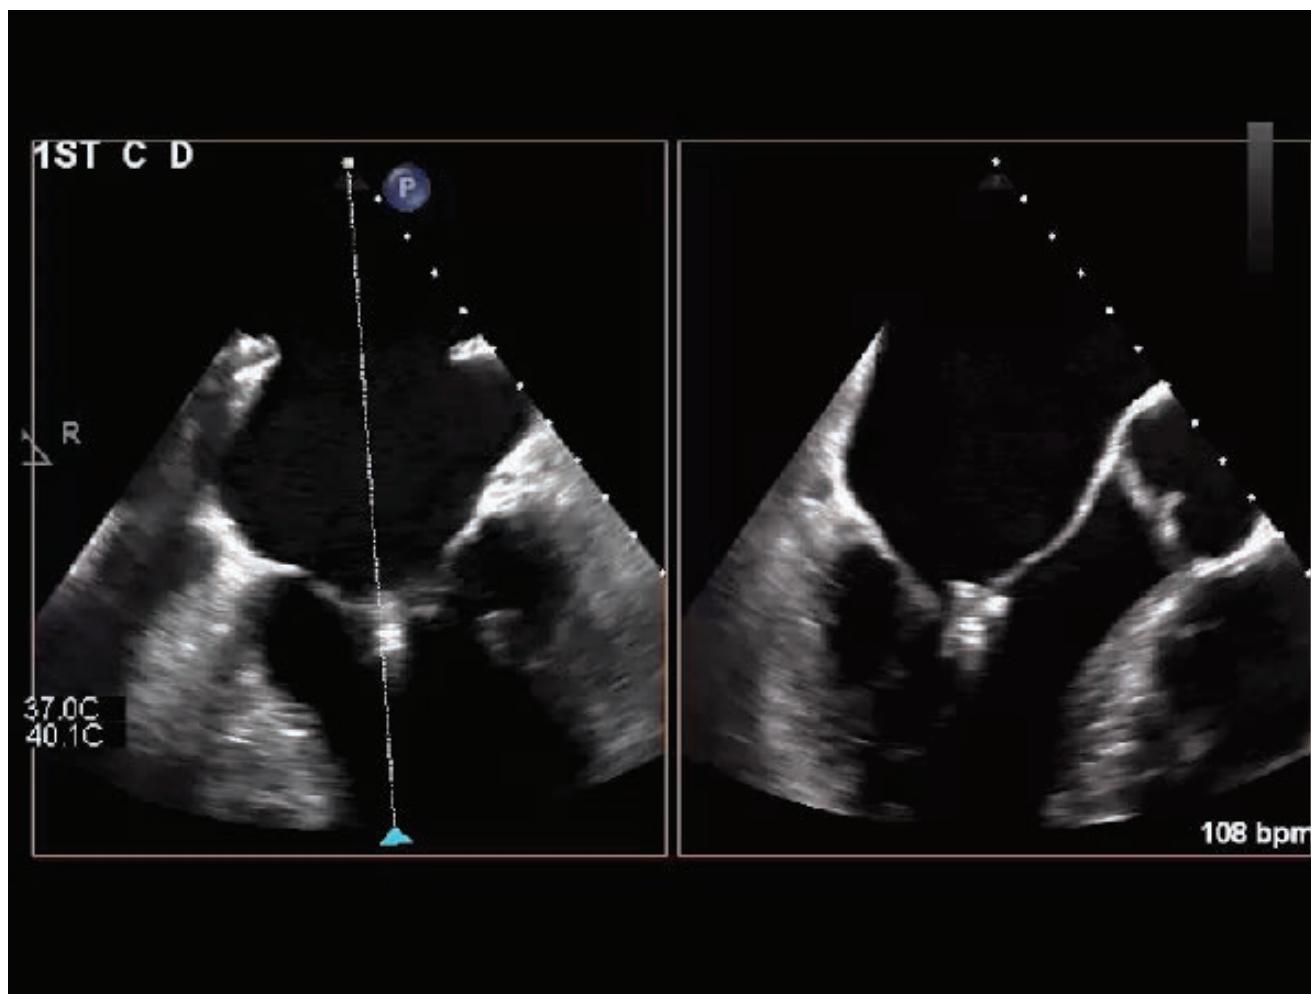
(video). Transesophageal Echo of SLDA with Clip Attached to Anterior Leaflet
